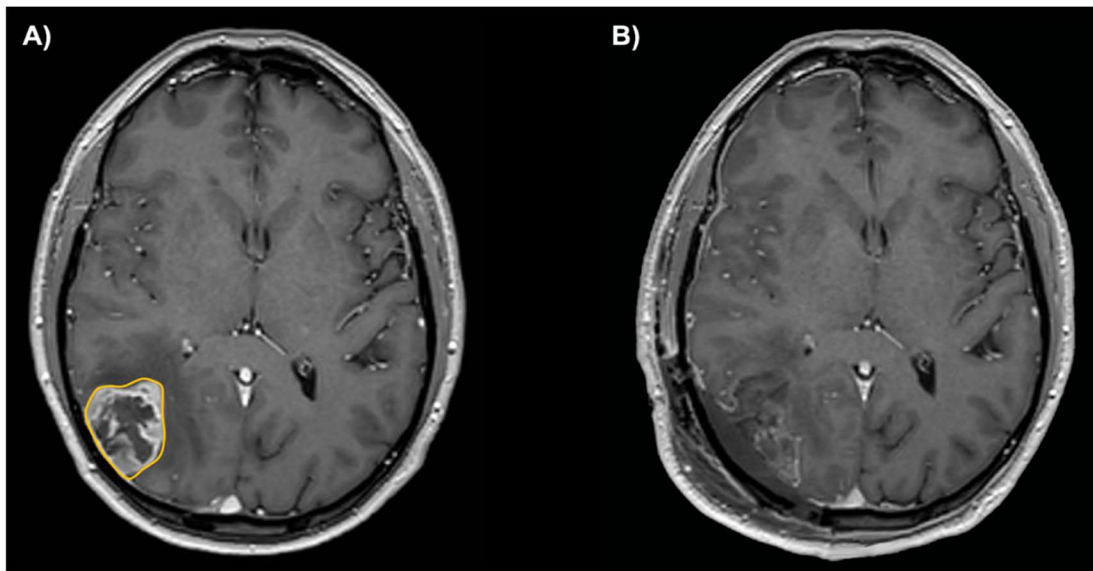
Preoperative (A) and postoperative (B) T1-weighted post-contrast axial images showing NTR with *absence of pathological enhancement* of surgical cavity.
